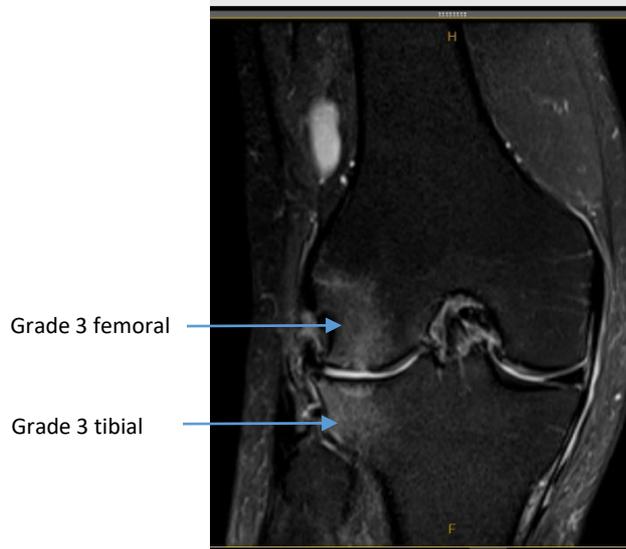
Grade 3 bone oedema in the lateral femur and tibia on coronal image (MRI image of a study participant).
